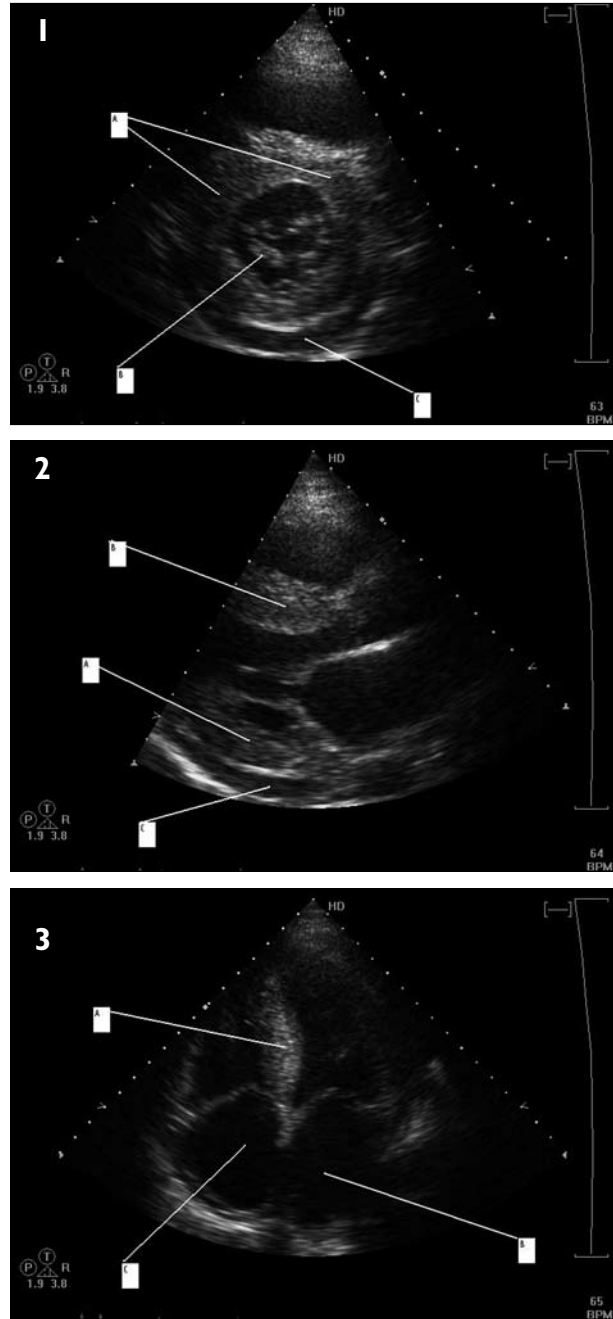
Echocardiogram suggestive of an infiltrative process from Case 1, whose CT scan at this stage showed features of cardiac failure. A coronary angiogram was normal. 1: Parasternal short axis view demonstrating a concentric thickened left ventricle (A) with thickening of the mitral valve leaflets (B). A small pericardial effusion is also demonstrated (C). 2: Parasternal long axis view demonstrating thickening of the left ventricular posterior wall (A) and septum (B) with the typical speckling appearance seen in cardiac amyloidosis. A pericardial effusion is again visualised (C). 3: A four-chamber view demonstrating marked hypertrophy of the inter-ventricular septum (A) with enlargement of the left (B) and right (C) atria.
